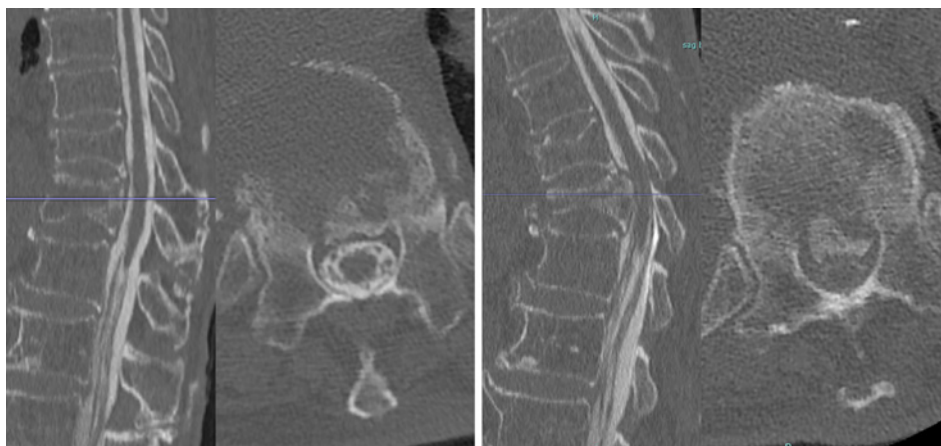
CT (left) in the supine position showing no compression of the spinal cord; however, flexion dynamic CT (right) reveals protrusion of occult bony fragment and spinal cord compression.
